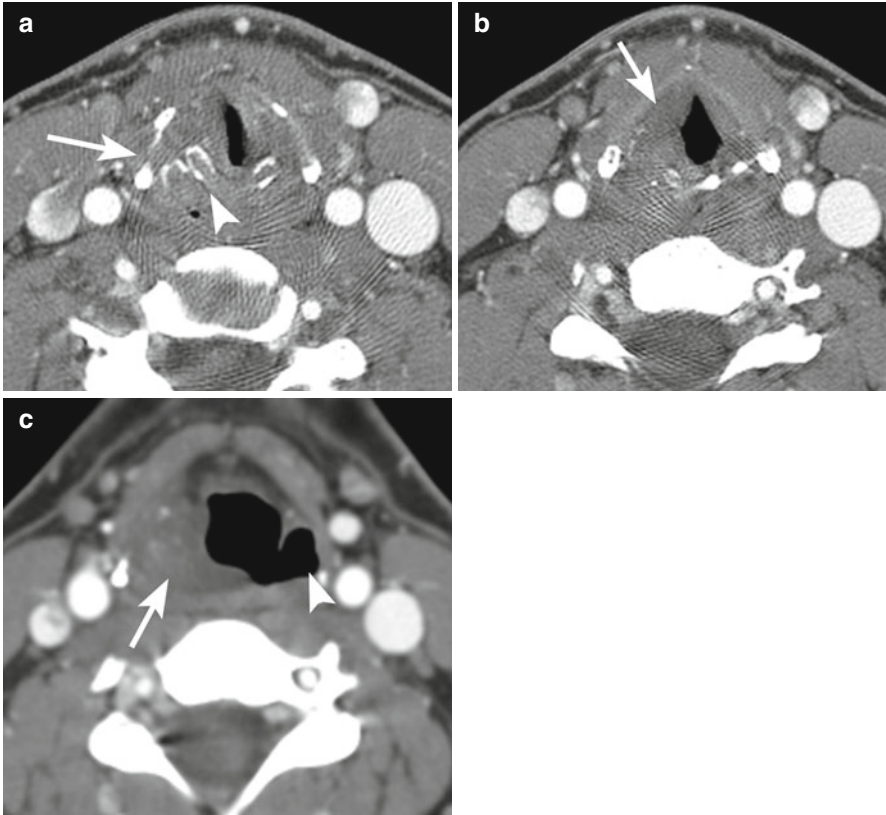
Contrast enhanced computed tomography (CT) examination of a patient struck in the neck with a baseball demonstrates: (a) Fractures of the right cricoid (*arrowhead*) and thyroid (*arrow*) cartilages with medial displacement and anterior displacement of the right arytenoid cartilage. (b) Soft tissue swelling and hemorrhage involving the true and false cords which extends up to the right aryepiglottic fold (*arrow*). (c) There is obliteration of the piriform sinus (*arrow*) and mild mass effect on the right side of the airway, which remains patent. The left piriform sinus is normal (*arrowhead*)
